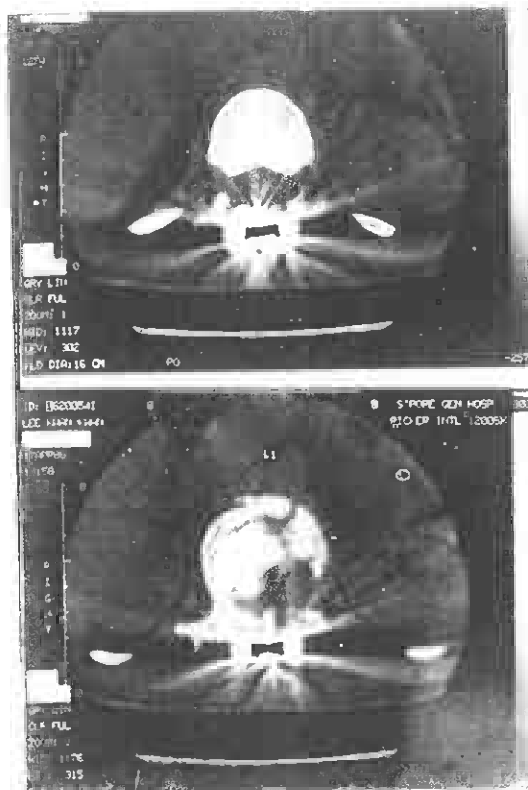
16-month follow-up radiograph of L.K.K.
